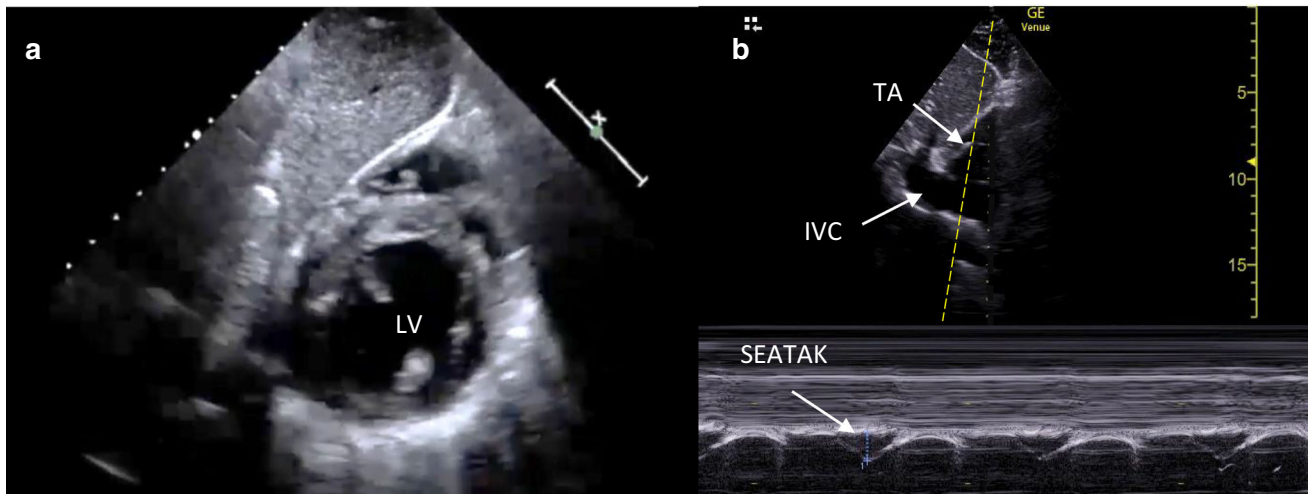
a) A subcostal short-axis view of the left ventricle at the midpapillary muscle level. b) Image of a subcostal echocardiographic assessment of tricuspid annular kick (SEATAK) being performed. IVC = inferior vena cava; LV = left ventricle; TA = tricuspid annulus
